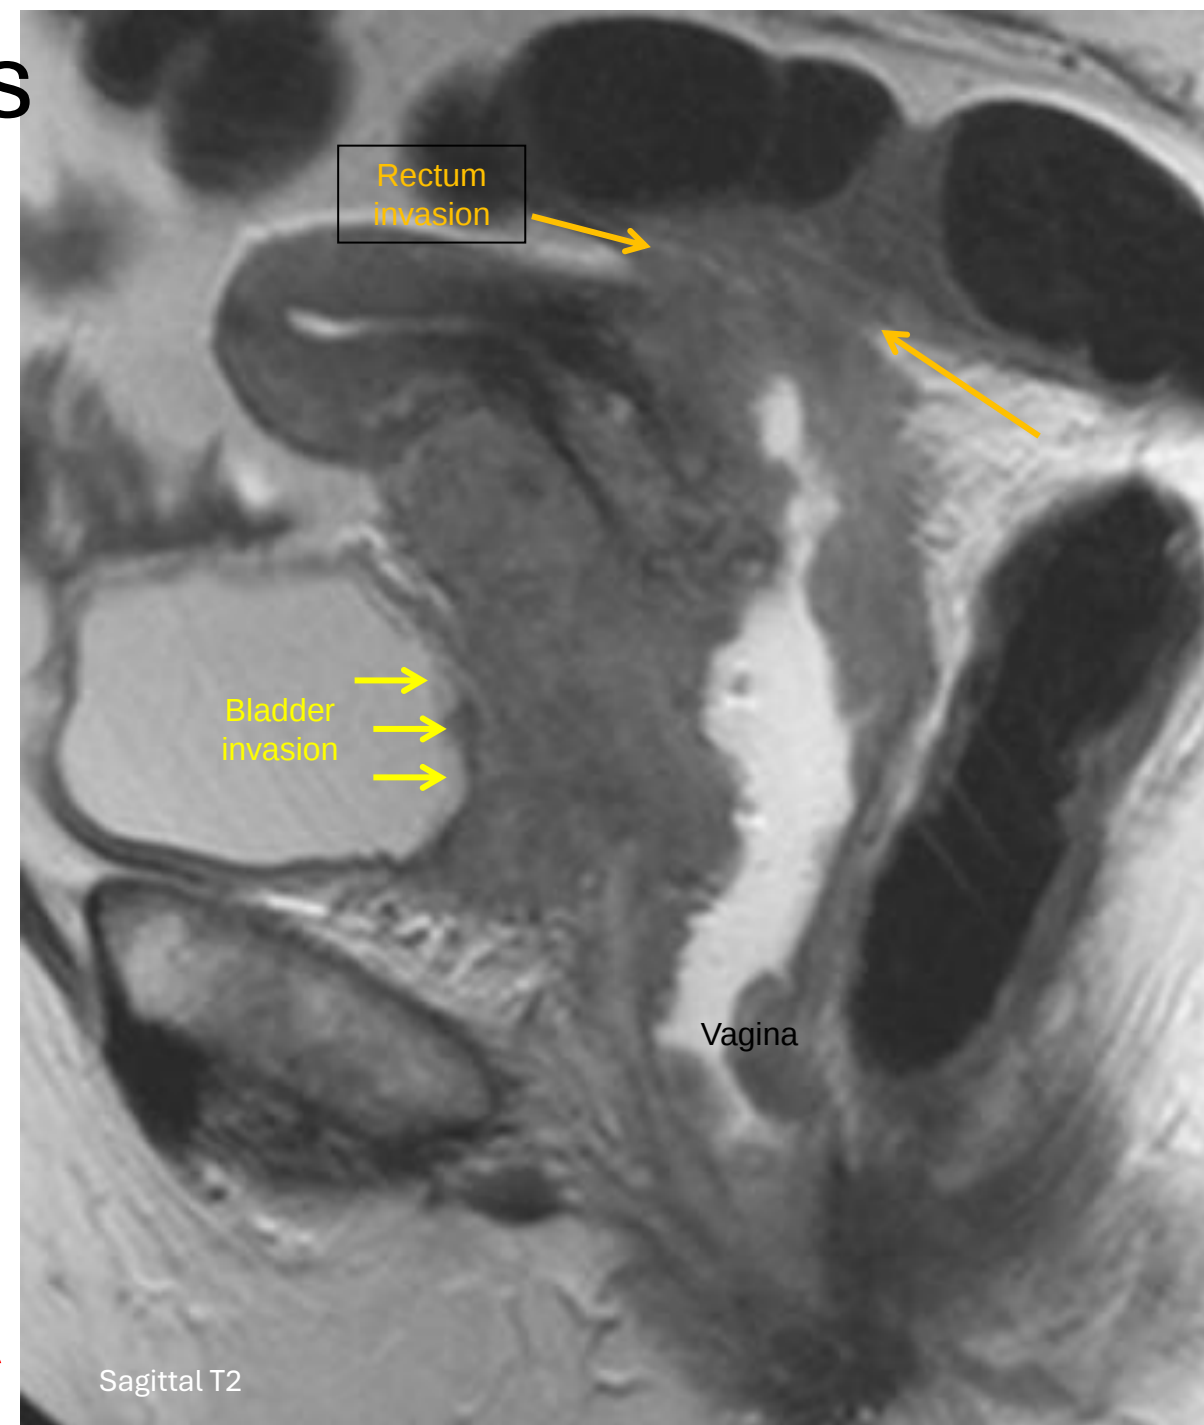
FIGO IVA staging parameters assessable by MRI
